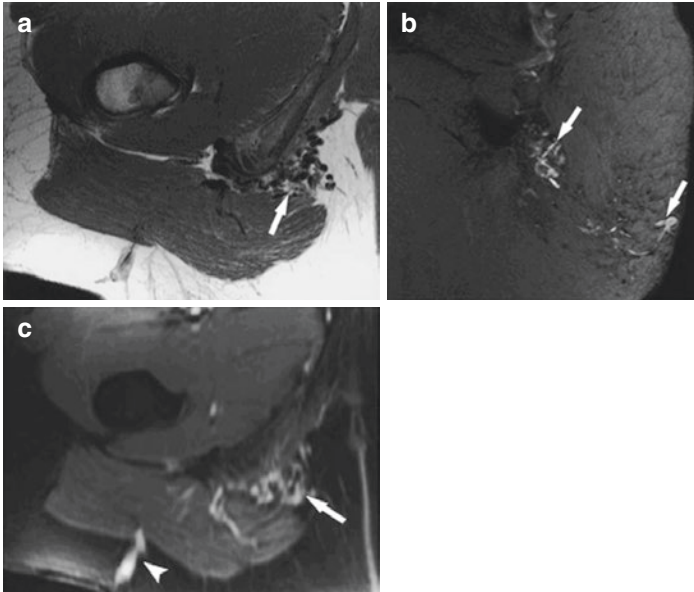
MRI of a high flow arteriovenous malformation (AVM). (a) Axial T1-weighted sequence shows numerous tortuous vascular spaces with flow voids (arrow) within an AVM of the ischial region with a characteristic lack of discernible “mass.” (b) Axial T2-weighted sequence reveals mixture of focal high signal intensity owing to turbulent or abnormal flow (arrows). (c) Gadolinium-enhanced fat-saturated sequence reveals hyperintensity with the arteriovenous nidus (arrow) and within venous drainage (arrowhead). (Reprinted with permission from [11])
